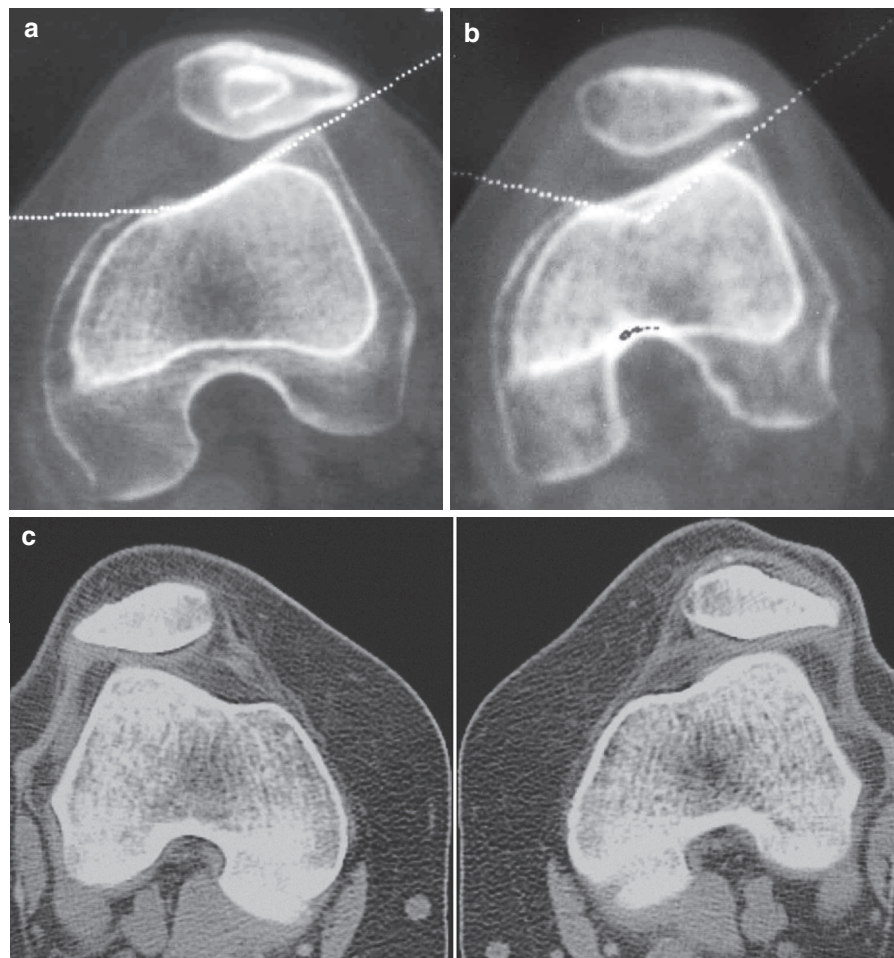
CT at 0° of knee flexion. (a) Preoperative CT: PFM. (b) At short-term follow-up after IPR, there is a correct patellofemoral congruence. (c) At long-term follow-up (13 years after IPR), we can observe a bilateral asymptomatic PFM (a – Reproduced from Sanchis-Alfonso et al.²⁸, Reprinted by permission from Thieme)
